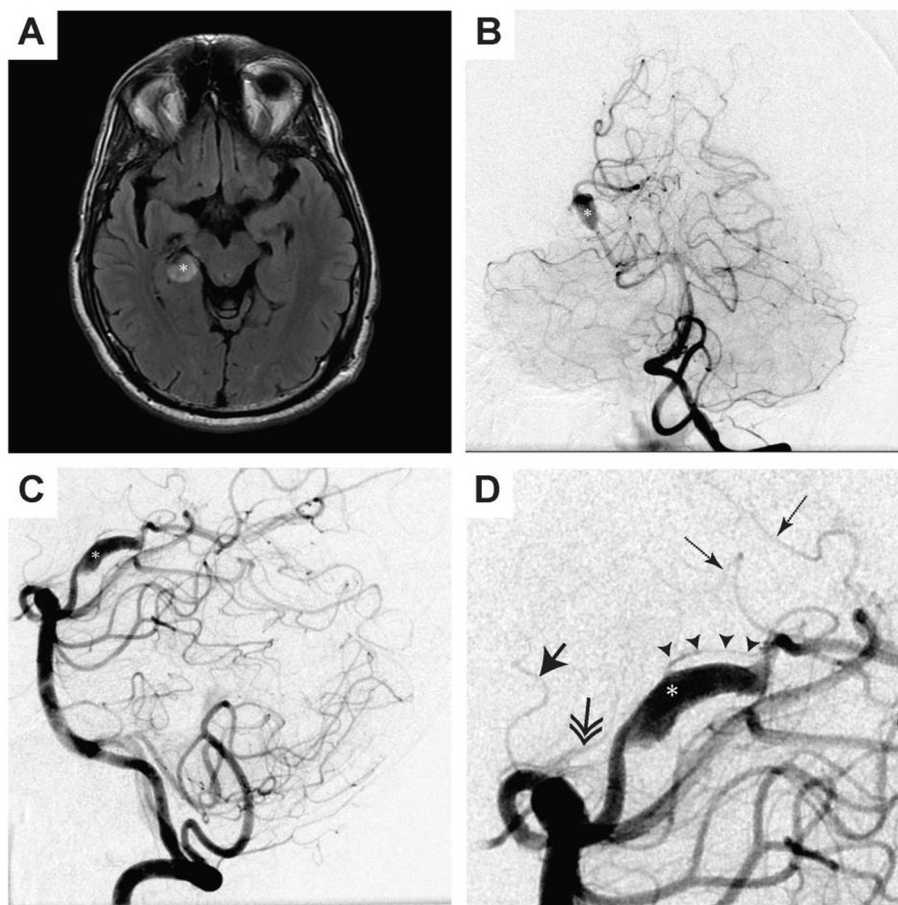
Pre-treatment Imaging. A. Axial FLAIR MRI demonstrating a rounded lesion in the right ambient cistern corresponding to a right PCA P2 segment aneurysm. B. Left vertebral artery angiogram demonstrating a partially thrombosed right PCA P2 segment aneurysm. C. Lateral projection left vertebral artery angiogram demonstrating the aneurysmal filling again. D. Magnified lateral projection left vertebral angiogram identifying a fusiform aneurysmal segment (asterisk) having a small thalamogeniculate perforator (arrowheads) originating from the aneurysmal segment; nearby perforators are also seen—the tuberothalamic artery (arrow), paramedian artery (double arrow), and the posterior choroidal arteries (dotted arrows).
